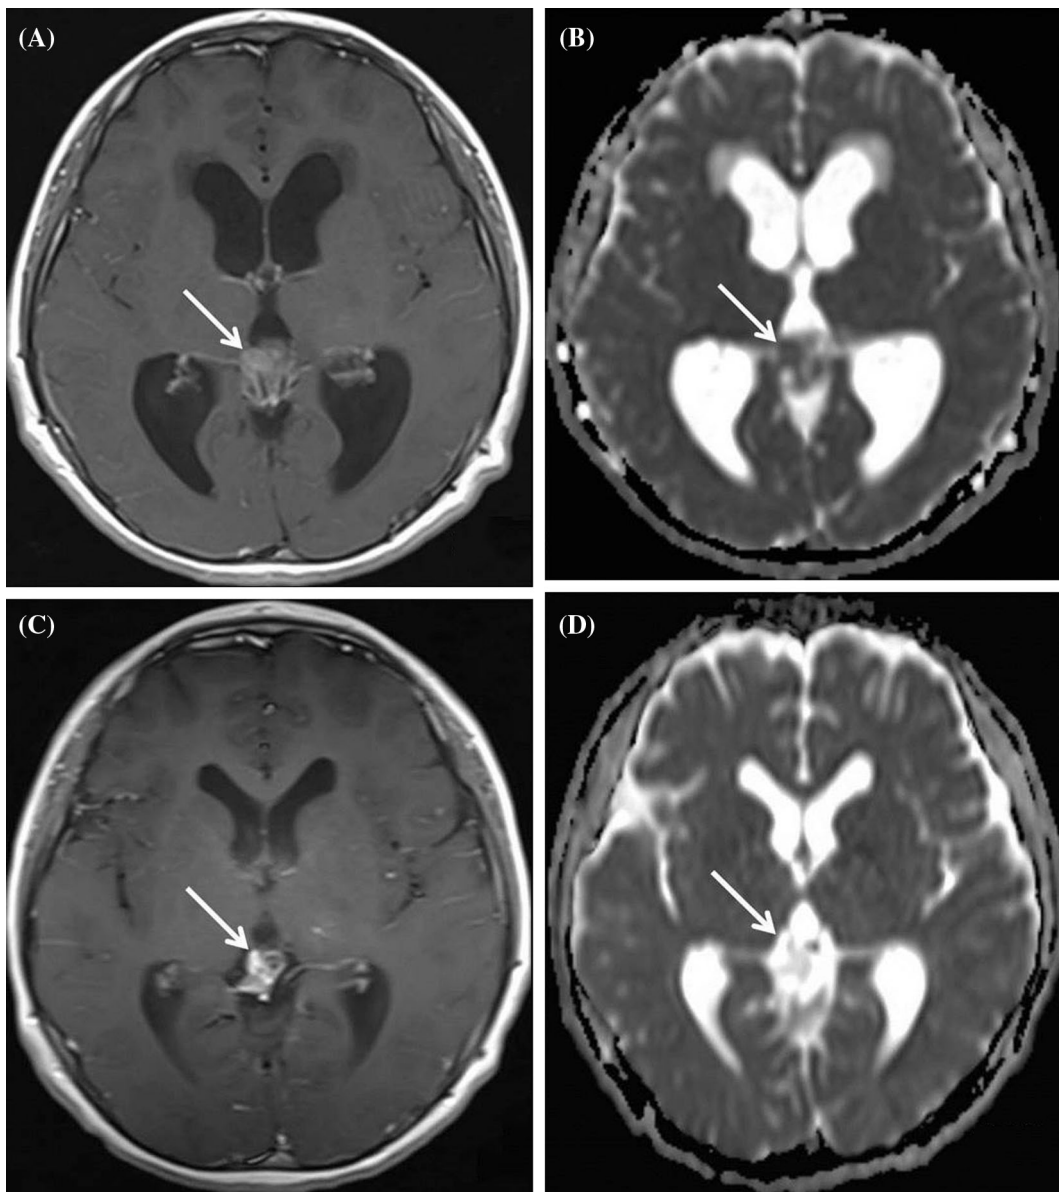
Magnetic resonance (MR) imaging from a 12-year-old boy with germinoma. Axial T1-weighted postcontrast (a) and apparent diffusion coefficient (ADC) (b) images obtained prior to initiation of chemotherapy demonstrated an enhancing pineal mass with restricted
